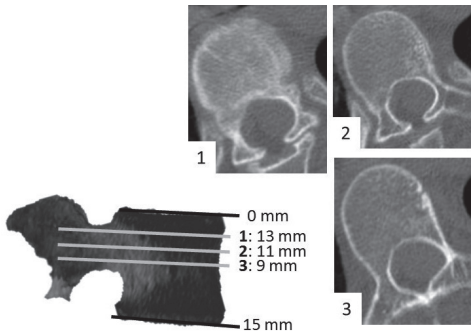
The measurement method and CT scans should be very accurate; slight deviation from the ideal transverse plane of the rotated, translated and tilted vertebrae automatically induces apparent, but not necessarily true asymmetry.
